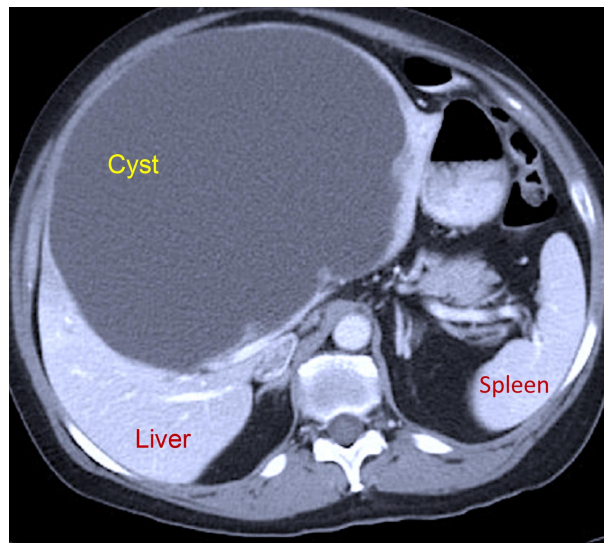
Computed tomography imaging of a solitary giant liver cyst of 18 cm in length, which occupied the central liver region and the left lateral hepatic segments.
